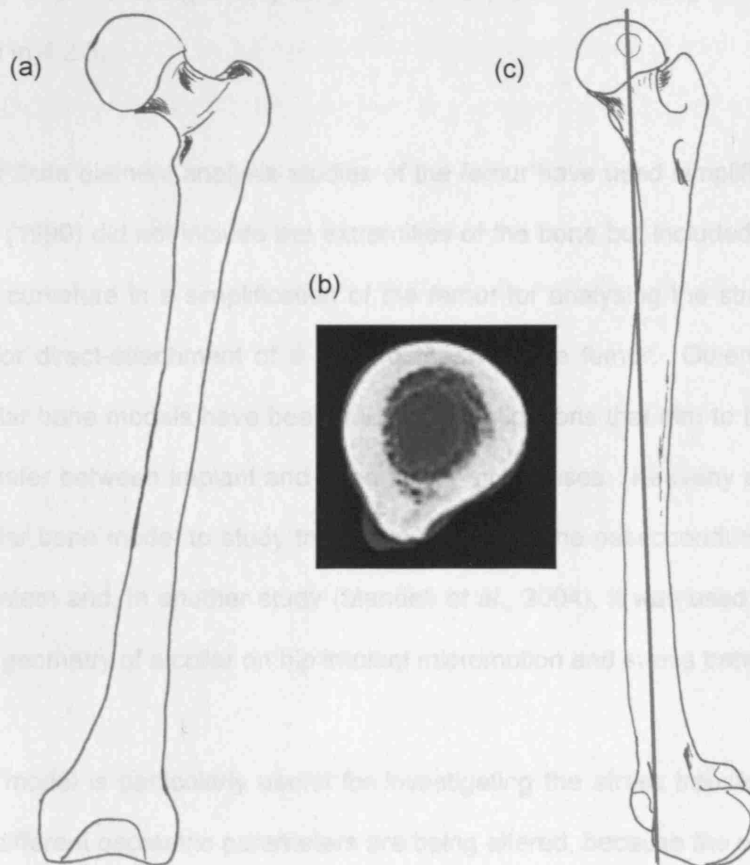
The anatomy of the femur; a) in the frontal plane, b) the cross-section in the mid-shaft, c) in the saggital plane. (a) and (c) adapted from Palastanga, Field and Soames (1998), (b) CT scan taken for use in this project.
